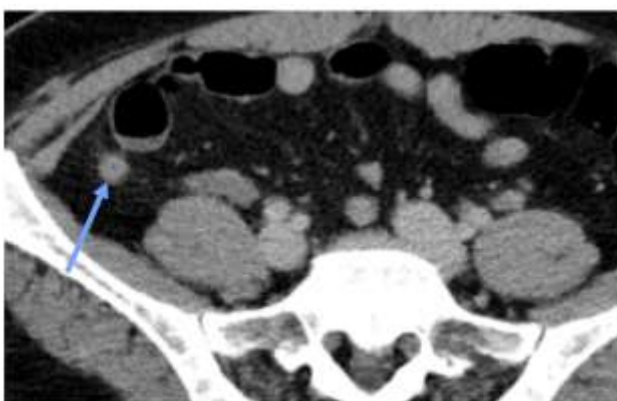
Axial CT with venous contrast showing a 5mm appendix (blue arrow) with minor fat stranding, reported as early appendicitis.
